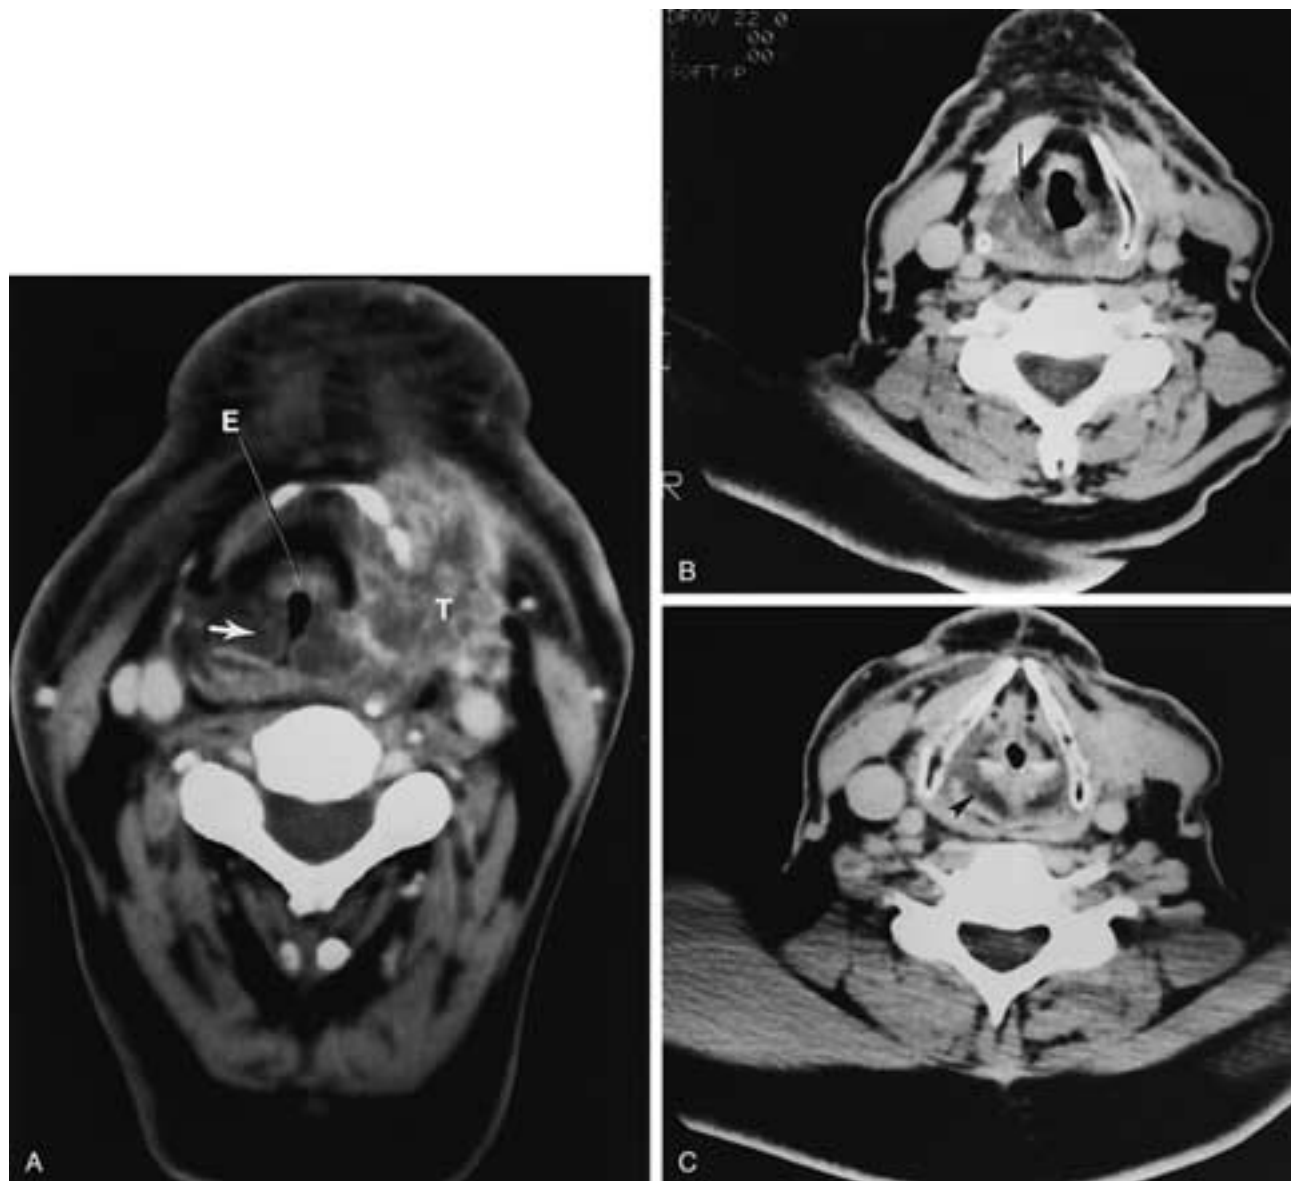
A, CT of postradiation tumor recurrence (*T*). Note the swelling of the AE fold (*arrow*) and apparent thickening of the epiglottic cartilage (*E*). B, Lower scan shows increased streaky density and thickening of the wall of the pyriform (*arrow*). Note also the streaky lymphedema ("dirty fat") in the fat anterior to the larynx. C, Scan through the upper arytenoid shows continued swelling in the soft tissues (*arrowhead*) posterior to the arytenoid.
